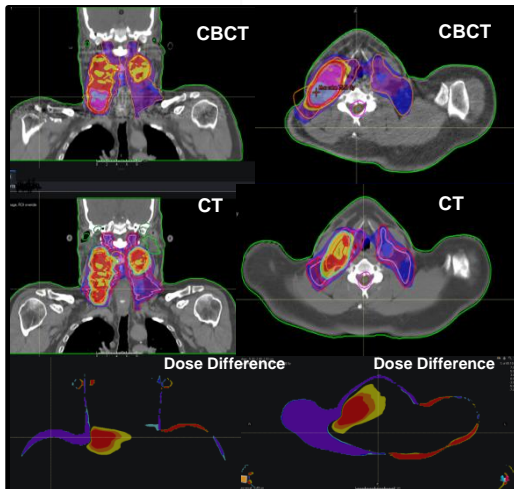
CT and CBCT Images (Coronal and Axial) of Patient A in a full Head and Neck Shell with calculated dose difference
